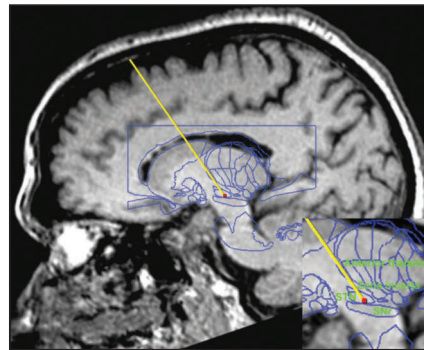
Microelectrode targeting the subthalamic nucleus in a patient with Parkinson's disease is shown on this MRI (magnetic resonance imaging) scan. Mount Sinai is the only center in New York State that combines microelectrode recording with intra-operative imaging, allowing more accurate and safer surgical treatment. Figure courtesy of Brian Kopell, MD
